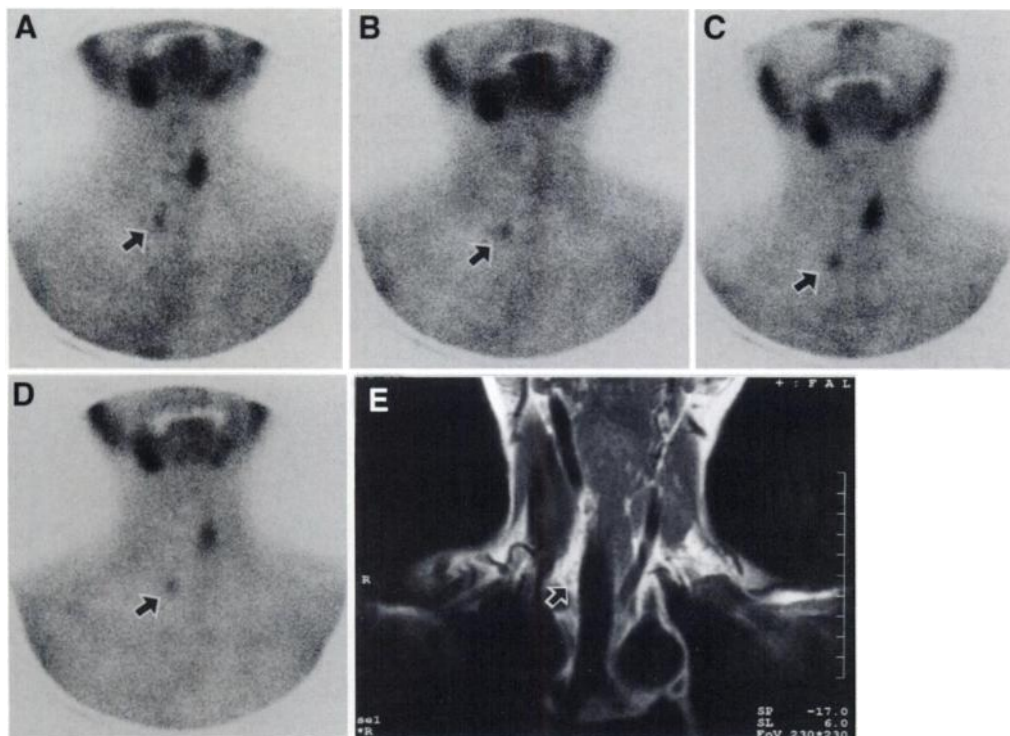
A 52-yr-old woman with an adenomatous ectopic parathyroid gland. Technetium-99m-MIBI imaging: (A) Early image showing the hemi-thyroid parenchyma increased uptake associated with an area of atypical focal uptake (arrow) in the thymus. (B) Late image showing thyroid uptake appears decreased while residual uptake in the ectopic parathyroid gland (arrow) in the thymus is visible. Technetium-99m-tetrofosmin imaging: (C) Early image showing the ectopic parathyroid gland (arrow) can be seen in the thymus to the same degree as with ^{99m}Tc -MIBI imaging. (D) On the late image, as with ^{99m}Tc -MIBI imaging, the ectopic parathyroid (arrow) is clearly visible on late images. (E) MRI image (T1-weighted image) showing a mass (arrow) in the thymus. At surgery, the patient was found to have an adenomatous parathyroid gland in that location. The weight was 0.8 g.
